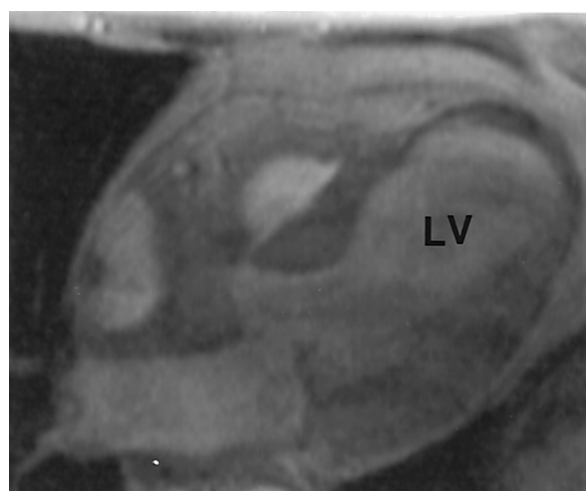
End-systolic, 4-chamber, long-axis cine MRI in the same patient as in Figure 1 before (*left*) and after (*right*) LV aneurysm repair, with the left ventricle (LV) as marked. The thinned apex can be readily seen before the operation in the left image. At right, the thinned region makes up much less of the apex, and the overall LV geometry is improved, with a reduction in end-systolic cavity area compared with that before the operation.
